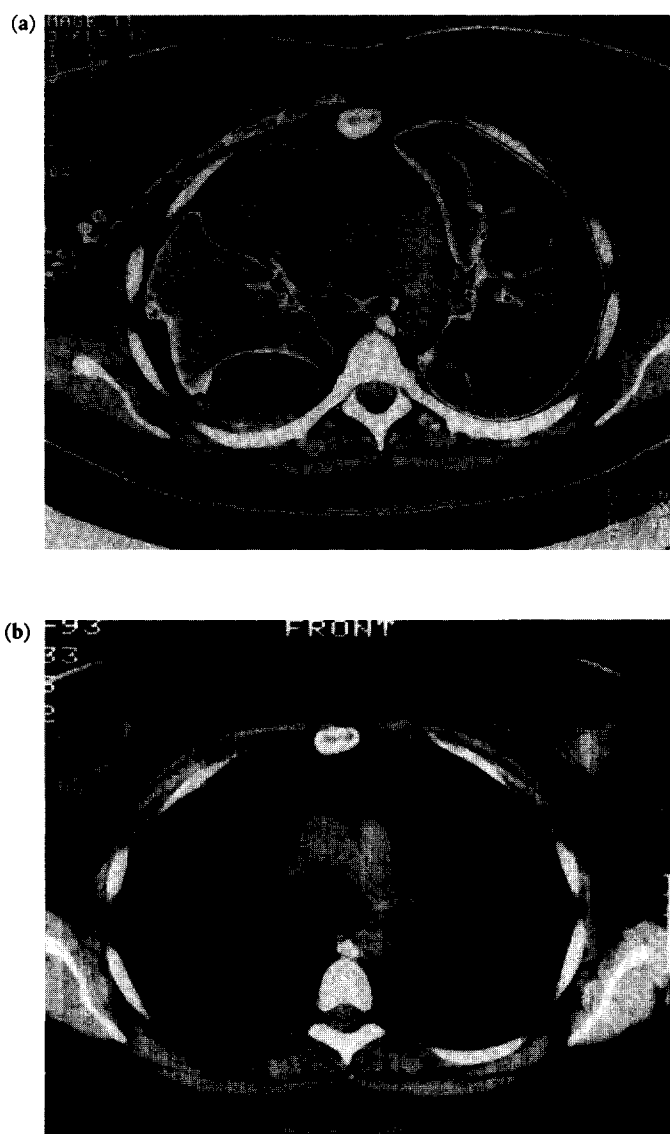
Computed tomography scan of the thorax of a patient with a large pleural mass due to metastatic melanoma (a) before and (b) after treatment with high-dose tamoxifen and fotemustine.
